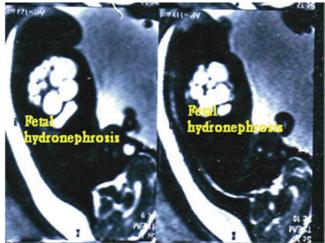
Fetal MRI shows fetal hydronephrosis.
